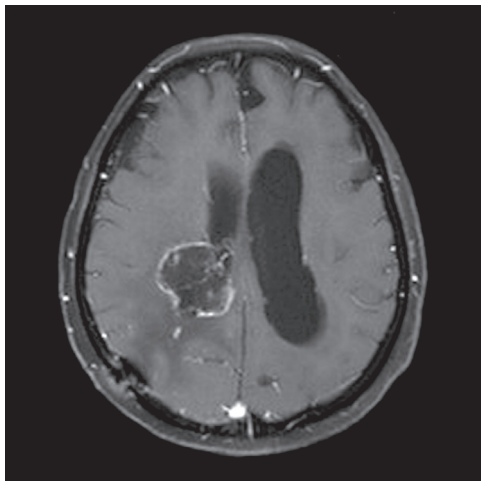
Gadolinium-enhanced magnetic resonance imaging (MRI) obtained 14 months later demonstrates necrosis of the tumor without growth.
